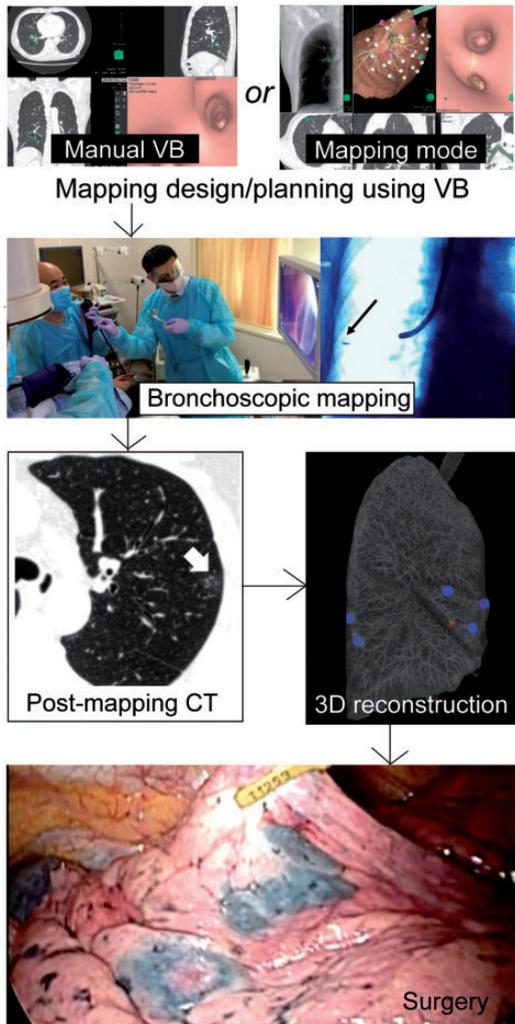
Steps in virtual-assisted lung mapping. A set of target bronchi can be selected using either manual virtual bronchoscopy or the mapping mode of the Synapse Vincent. According to the preoperative plan, bronchoscopic dye marking is conducted using standard fluoroscopy. Within 2 to 3 h of the procedure, post-mapping computed tomography is performed to confirm the locations of the markings and target tumor. The computed tomography images are reconstructed into 3-dimensional images. Finally, surgery is carried out using the 3-dimensional image as a guide. 3D: 3-dimensional; CT: computed tomography; VB: virtual bronchoscopy.
